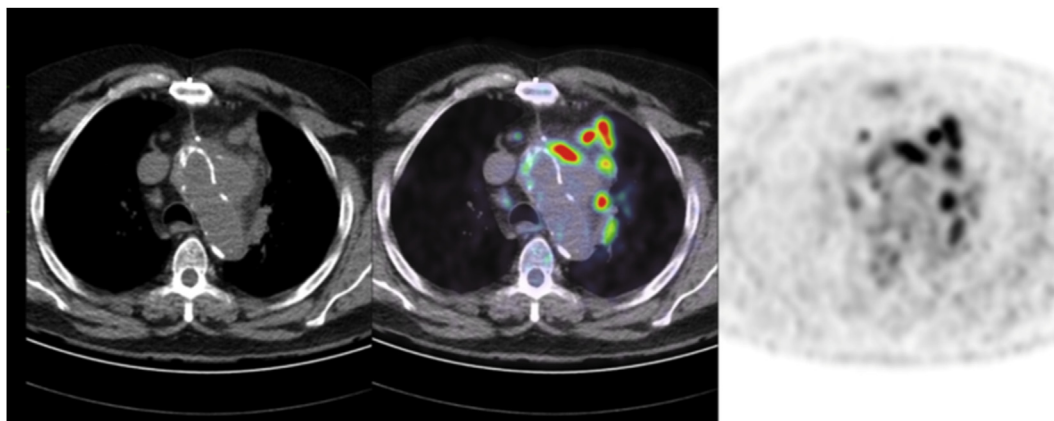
Coronal and axial view of fused FDG-PET/CT showing increased FDG uptake at the level of the thoracic aortic cross pseudoaneurysm wall (SUVmax : 8.2) and multiple mediastinal adenopathies (SUVmax : 7.9).
